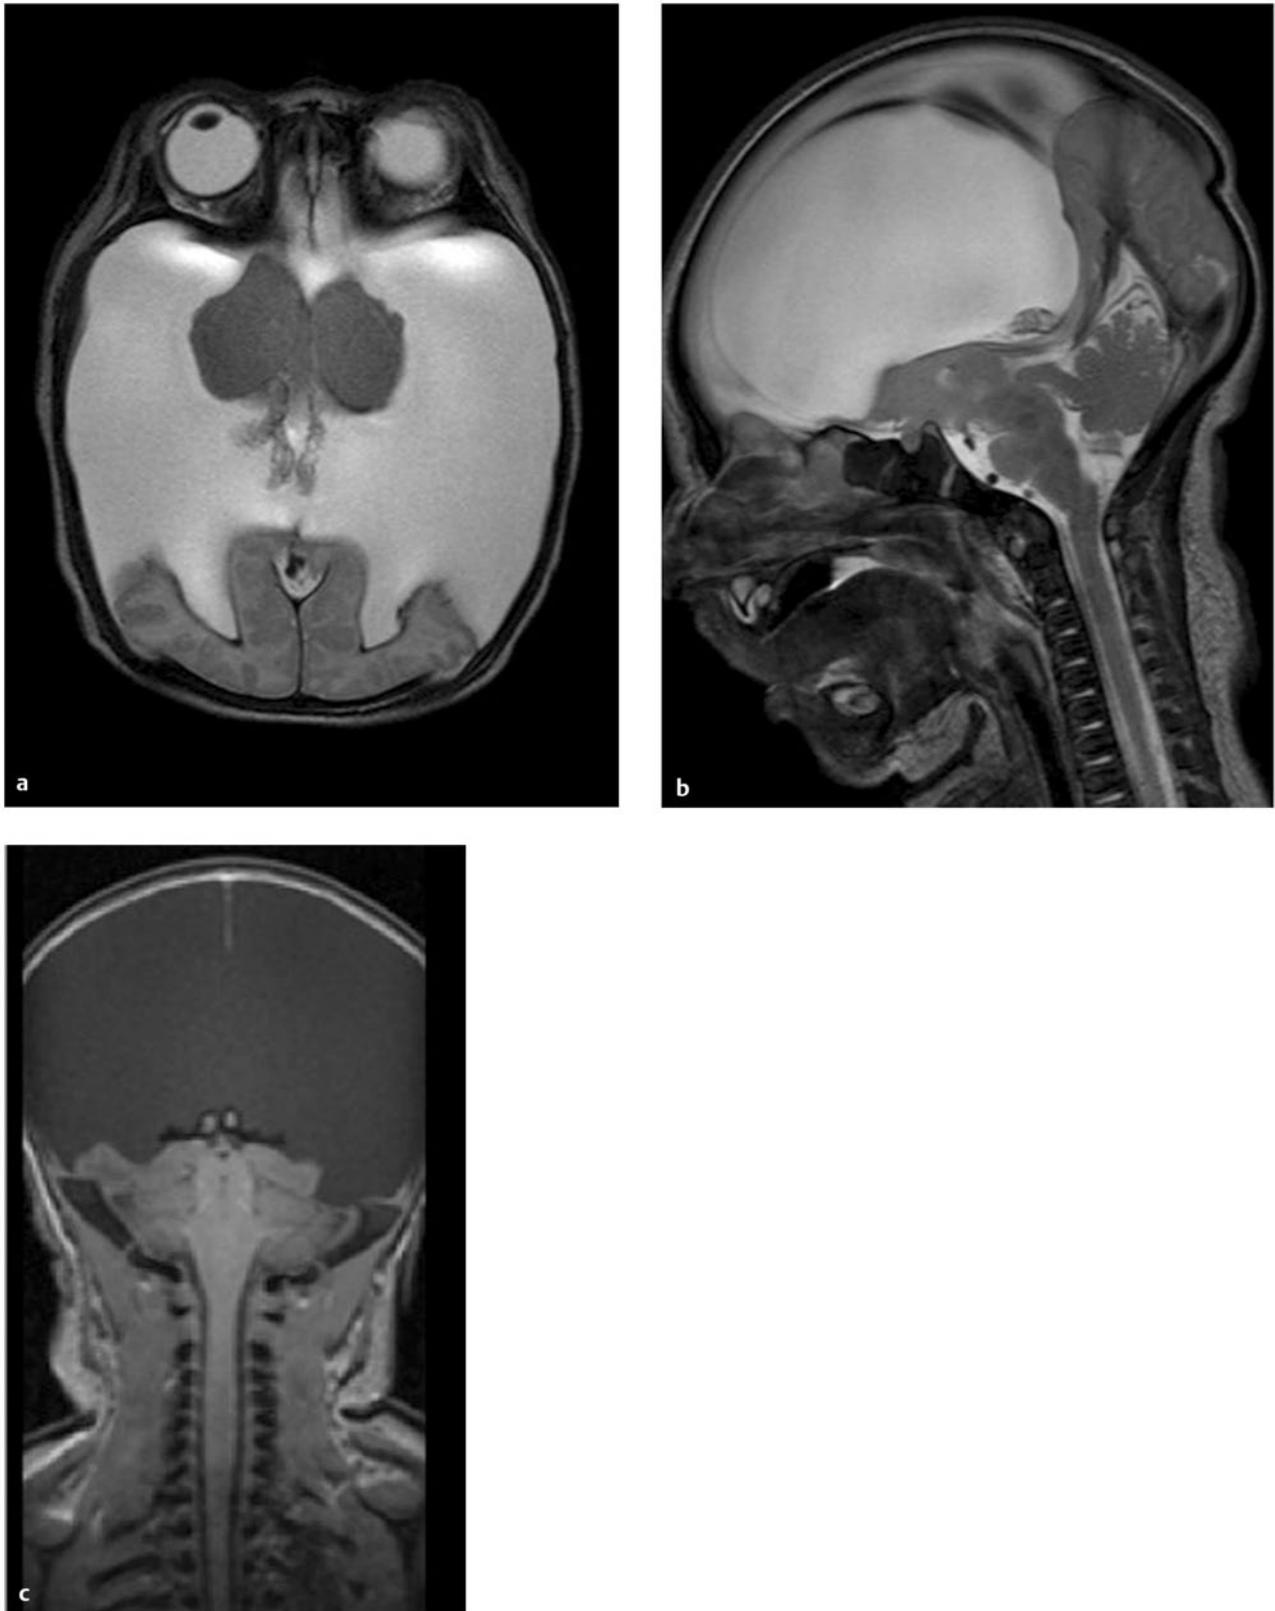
Gradient-echo axial (a) and sagittal T2-weighted (b) and coronal T1-weighted (c) magnetic resonance images of child with hydranencephaly. The cerebral hemispheres, except for a thin rim of the occipital cortex, are absent and replaced by cerebrospinal fluid. The thalamus, brainstem, and cerebellum are preserved. Unlike in HPE, the falx is fully formed.
